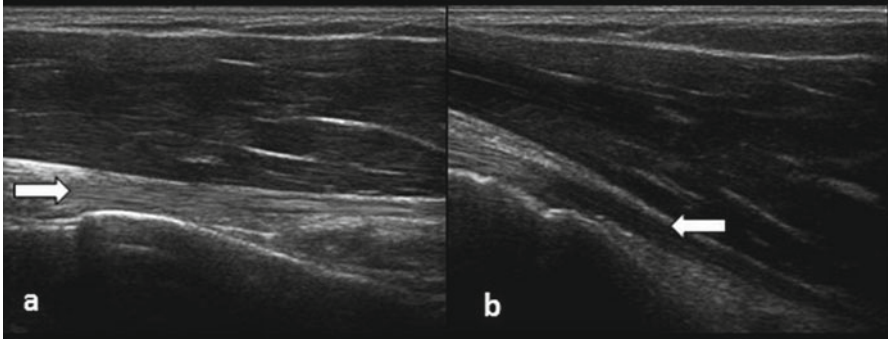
Ultrasound image of a biceps tendon (*arrows*) (a) without and (b) with anisotropy
